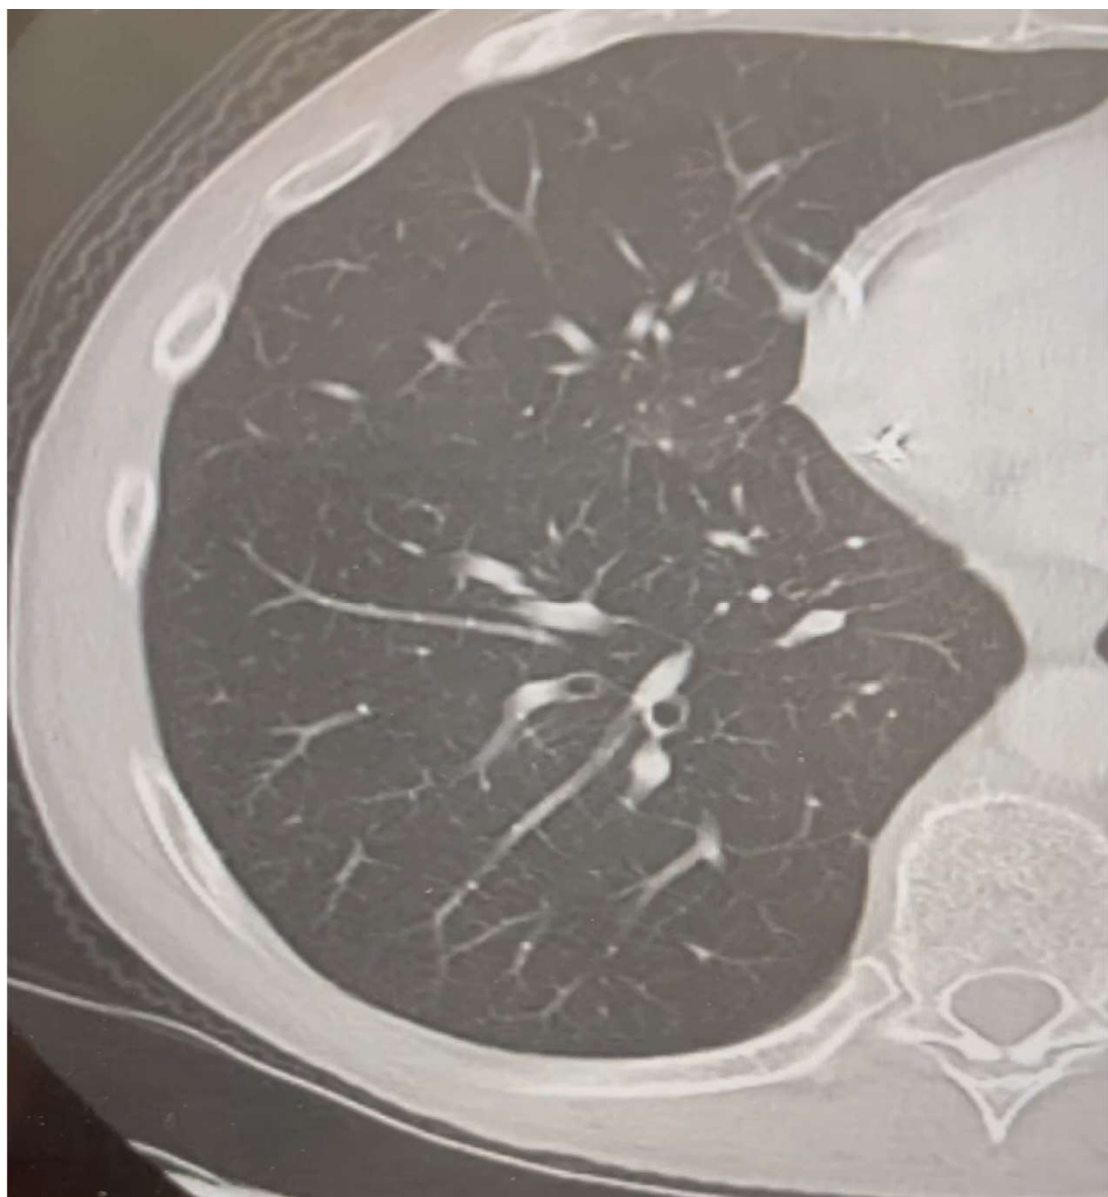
Case 1. Pathway, augmented fluoroscopy, radial EBUS and CT scanning pre and post injection. A – Monarch platform planning software image showing the scope aligned and positioned at 3 cm from the target. B – BodyVision confirmation of needle in target. C – Radial EBUS showing an eccentric lesion. D- CT before NBTXR3 injection; E- CT scan after NBTXR3 injection, performed for radiotherapy planning, showing the hyperdense radiopaque material
